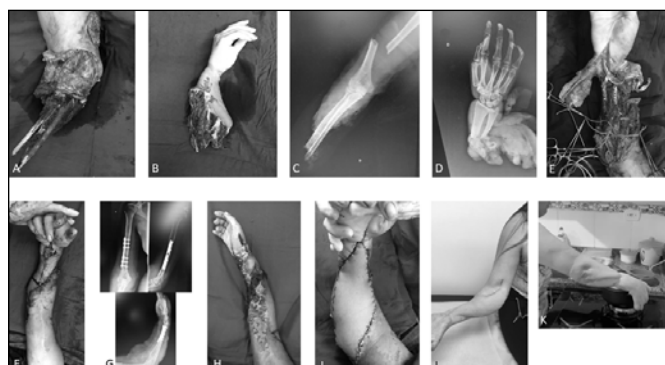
Case 3: (A and B) Upper limb and amputated forearm; (C and D) Radiographs of the upper limb (showing an ipsilateral fracture of the humerus) and amputated forearm; (E) Intraoperative imaging with isolated vessels; (F) Final surgery image; (G) Postoperative X-ray with humerus, radius, and ulna synthesis; (H) Evolution with necrosis of the skin and of the soft portions of the anterior forearm; (I) post-surgery image of the anterolateral flap of the thigh for forearm coverage; (J) Final image of the upper limb; and (K) Evidence of function for activities of daily living.
